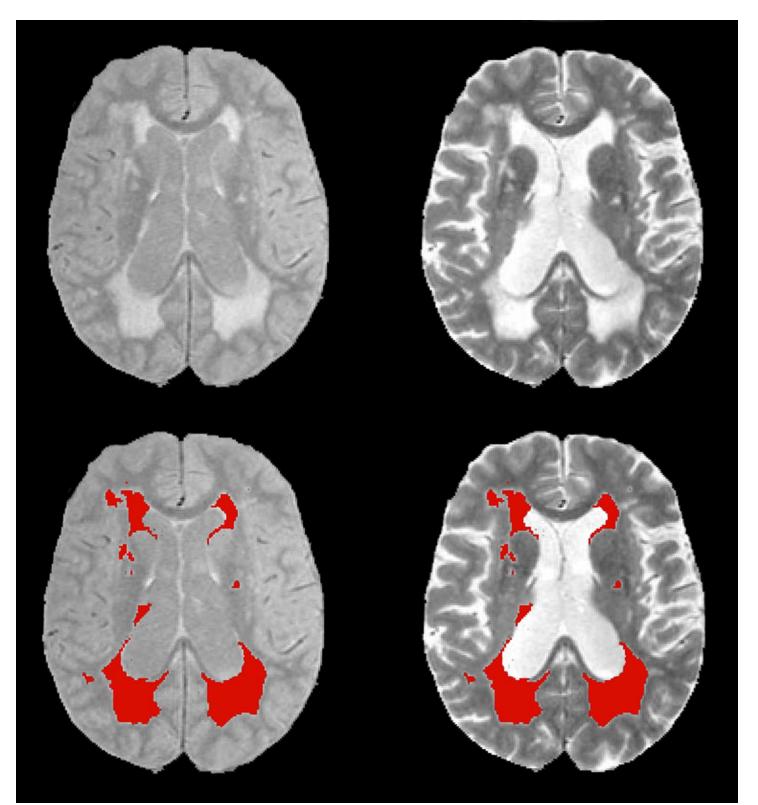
Proton density (PD) and T2-weighted MRI showing white matter hyperintensities of presumed vascular origin (WMH) [15] segmentation in red. WMH volumetrics for SDS, ADNI1, and 3C were obtained from PD/T2-based segmentations.
